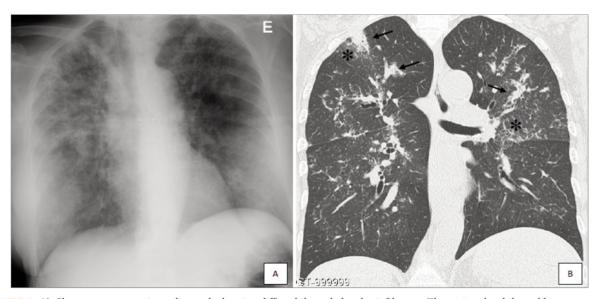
A) Chest postero-anterior radiograph showing diffuse bilateral alveolar infiltrates. The patient has bilateral breast implants; B) Chest Computed Tomography coronal image showing confluent peribronchovascular nodules with areas of consolidation (arrows) and surrounding ground-glass opacities (*). There were no signs of cavitation.
